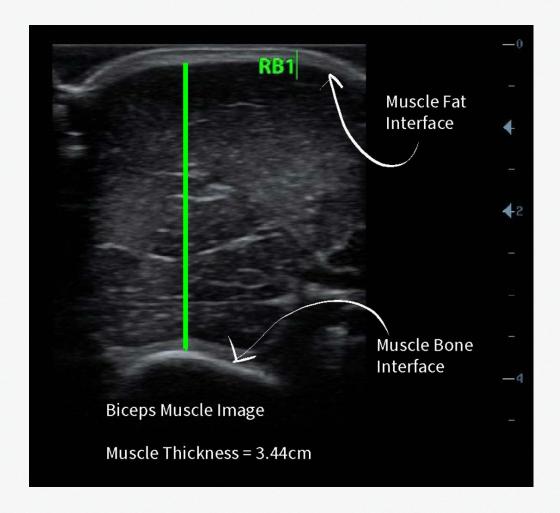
displays a B-mode ultrasound image of the biceps. Within the image, the muscle fat interface and the muscle bone interfaces are labeled. The Green line represents how muscle thickness is measured (from interface to interface). The biceps image provided is a female biceps with a thickness of 3.44cm.
